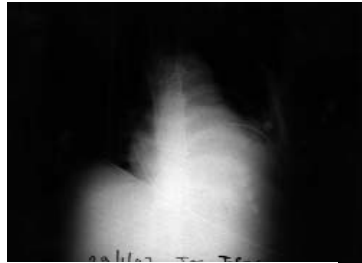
X-ray of the same patient after 27 days (five days after cardiac transplantation and ablation of the sliding staple-splints)
